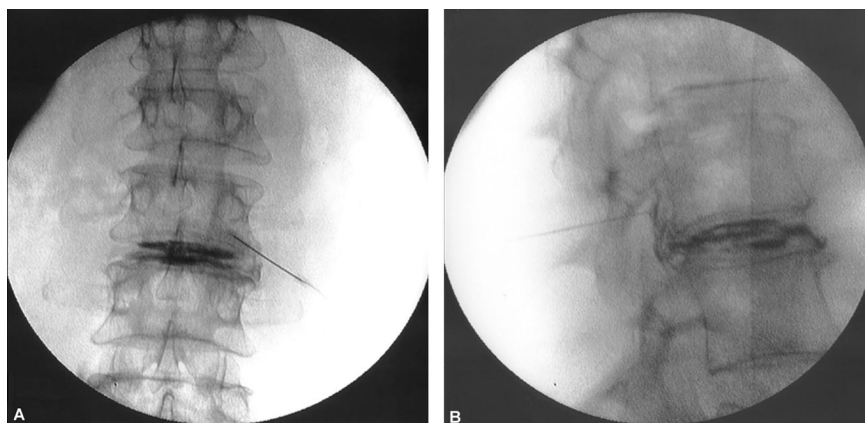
(A) Anteroposterior radioscopic view of the lumbar spine with the patient in the prone position. The x-ray module is positioned in a posterior-anterior position. Needle position under the L3 pedicle is visualized; 0.5 ml dye (180 mg iodine per ml iohexol, Omnipaque®) is injected through the needle, resulting in a clear discogram of the L3-L4 intervertebral disc (the right side of the figure is the right side of the patient). (B) Lateral radioscopic view with the patient in the prone position, showing descending dye from the tip of the needle in the neuroforamen to the intervertebral disc, beside the discogram.
